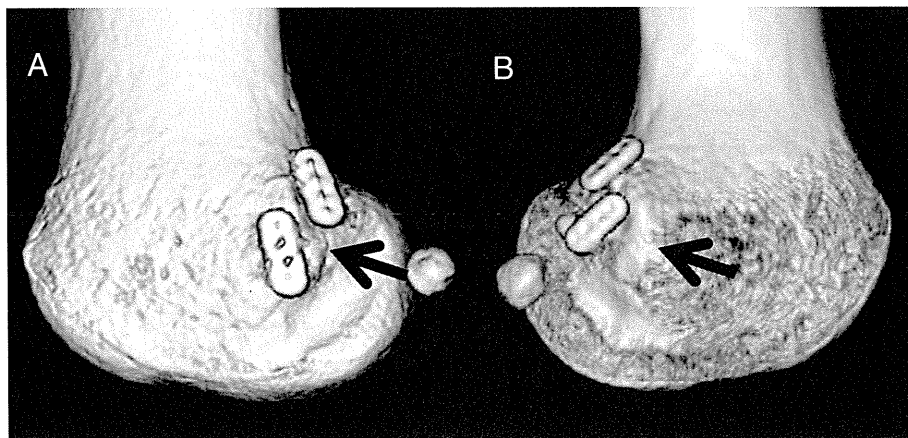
Postoperative three-dimensional computed tomography of Case 1 (A) and Case 2 (B): Each Endobutton for the posterolateral bundle was placed near the lateral epicondyle in both cases. Black arrows showed the lateral epicondyle of the distal femur.
